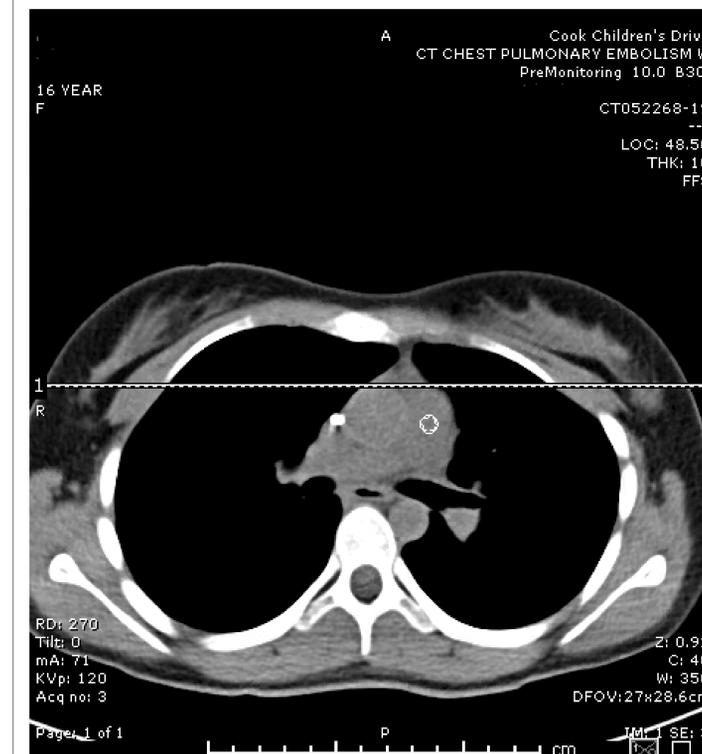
CT Scan of chest (3/19) showing large thymic cyst.
